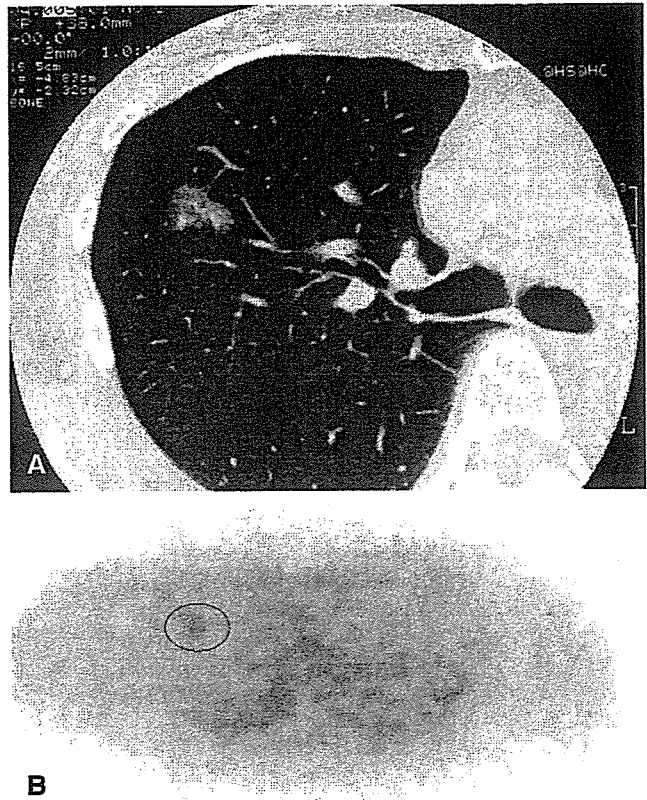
(A) Computed tomography findings of well-differentiated adenocarcinoma with ground-glass opacity findings. (B) Acetate-positron emission tomography showed positive at the tumor (encircled).
